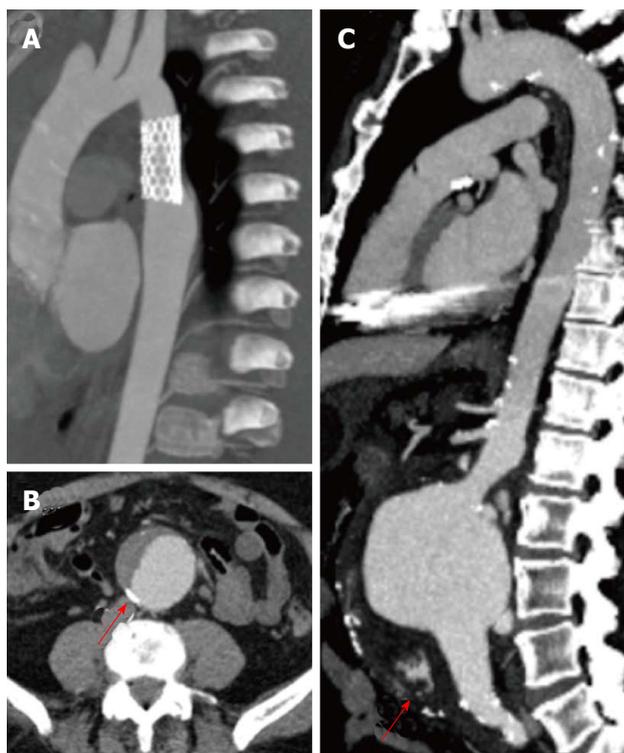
Aortic computed tomography. A: Patient with vascular endoprosthesis, without vascular leaks; B: Dissected abdominal aortic aneurysm, arrow points to calcified atherosclerotic plaques; C: Ruptured infrarenal aortic aneurysm, seen as hyperdense material in the abdominal cavity (arrow).
